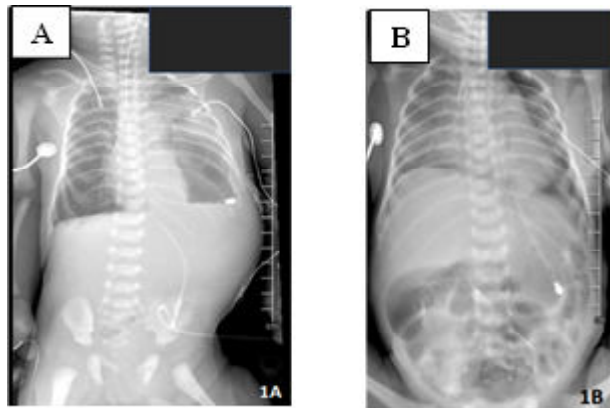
(A) Chest X-ray with the presence of bowel loop in the left hemithorax; (B) Plain abdomen X-ray with dilatation of small bowel loop.
